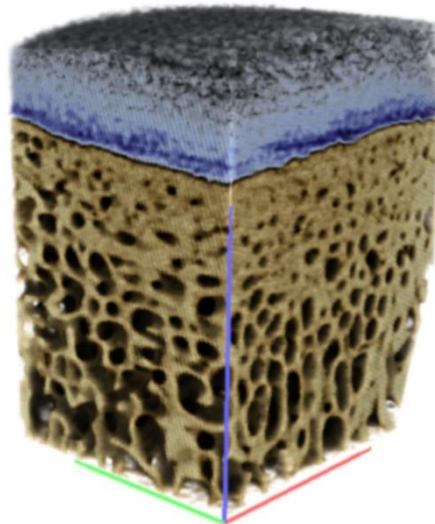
3D rendering of the sample acquired with the S μ CT system. The blue palette displays iodine content (darker at higher concentrations), the light brown palette displays the HA distribution. Reproduced under the terms of the CC BY 4.0 license. © 2024 Fantoni et al.
